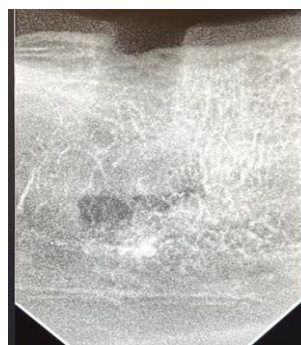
a, b, c. X-ray after removal filling material 1 month after removal filling material
